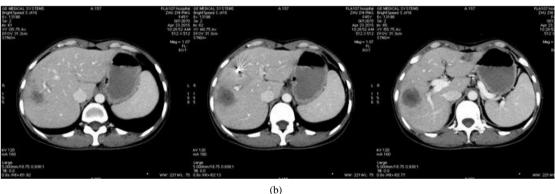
CT revealed that tumor lesions are became decreasing with rhIL-12 treatment. (a) CT before rhIL-12 therapy (2015-01-28); (b) CT afte rhIL-12 therapy (2015-03-11).
